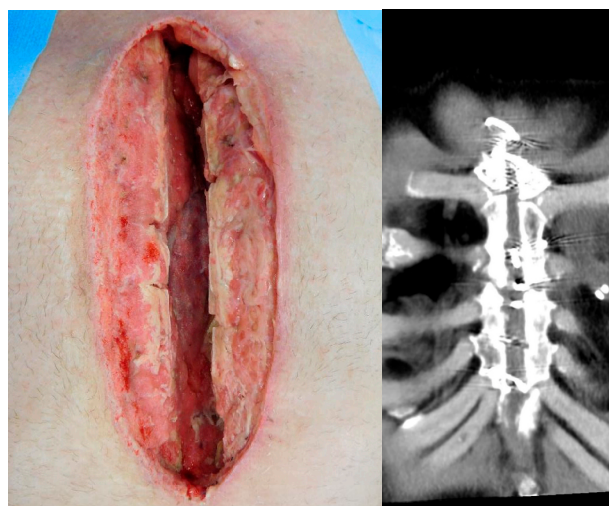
Example of grade II pathology. Good bone substance, but some transverse fractures and small defects due to torn wire cerclages in both sternal halves. (Left) Intraoperative situs immediately before reconstruction. (Right) Pre-operative CT of the anterior chest wall (soft-tissue window).
